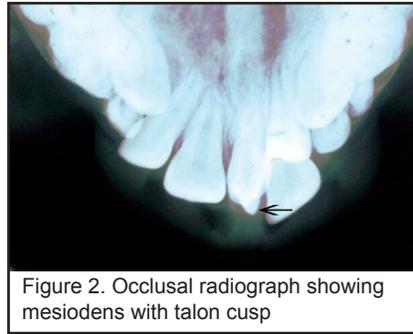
Occlusal radiograph showing mesiodens with talon cusp
